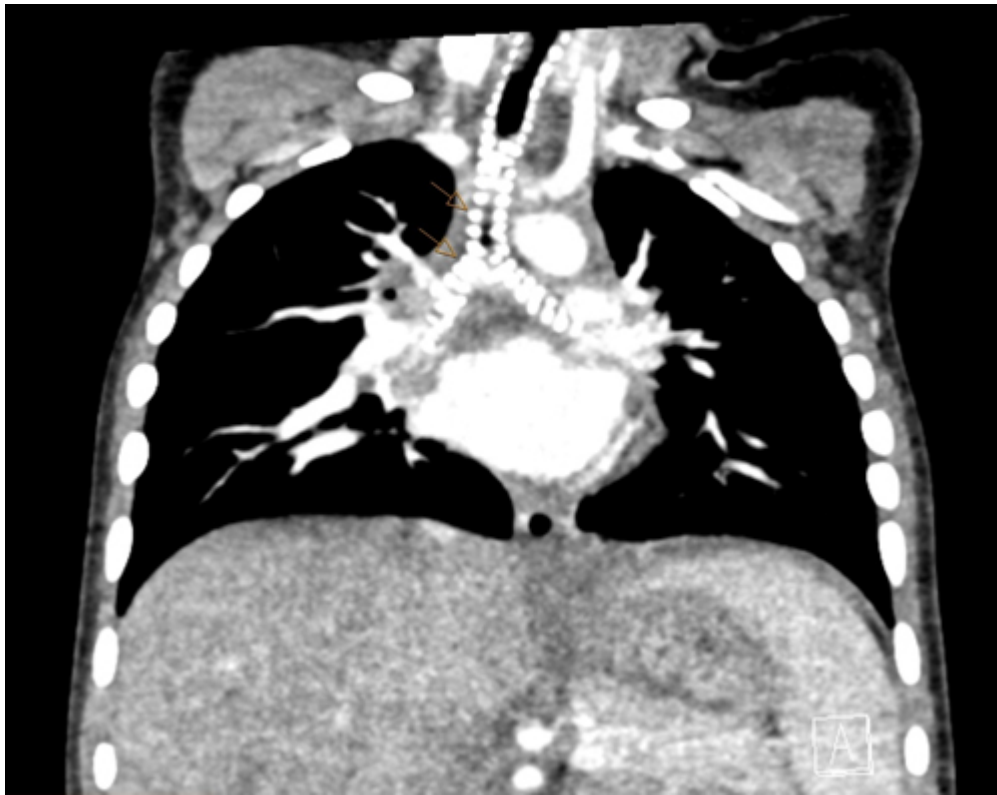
CT confirmed dense calcifications of the tracheal and bronchial cartilages.
